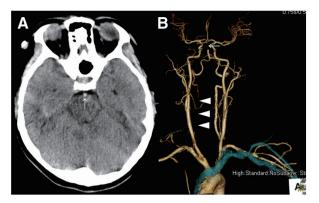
Hyperdense artery sign was positive on head CT on admission, and acute BAO was suspected (arrow). (A) BAO from mid basilar to basilar top is shown (arrow), and V1 and V2 segments of the right VA were not well enhanced (arrowheads) on CTA (B). BAO: basilar artery occlusion
